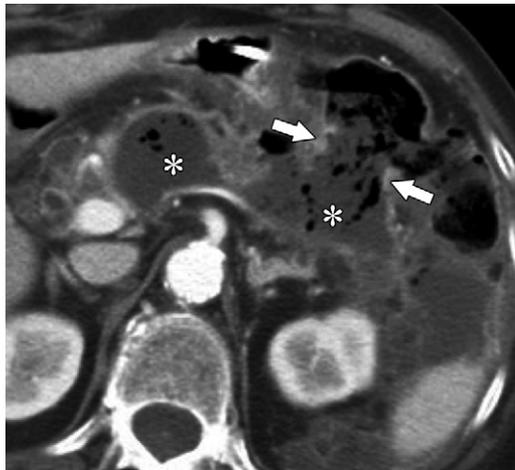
Necrotizing pancreatitis in a 74-year-old woman. Axial contrast-enhanced CT image obtained at 5 weeks shows peripancreatic WON with multiple foci of gas (*). A large fistula is seen to the distal transverse colon and contains gas and fluid (arrows), a finding that explains the development of gas in the WON.
